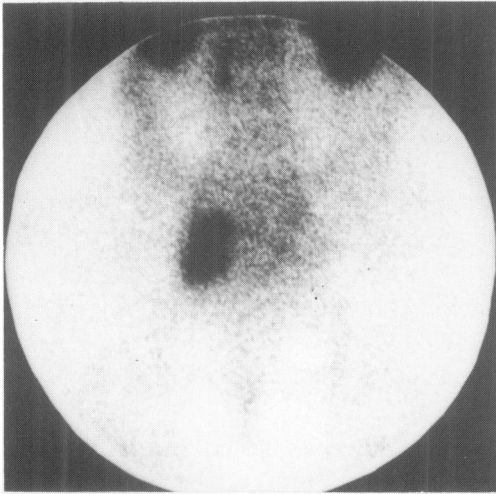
Pelvic recurrence of a sigmoid adenocarcinoma (1 year after primary tumour resection) as shown by immunoscintigraphy (posterior view 24 h after injection of ^{99m}Tc-BW 431/26).
